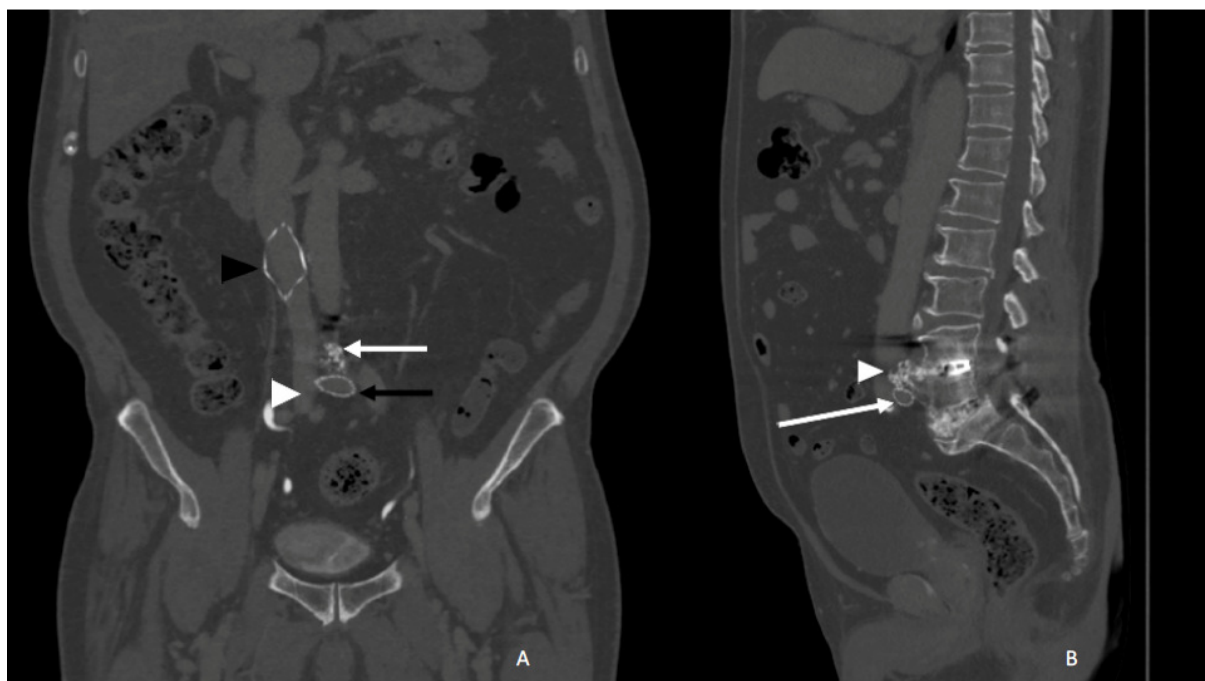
The 3-D computed tomography (CT) angiography obtained at 14 months postoperative
